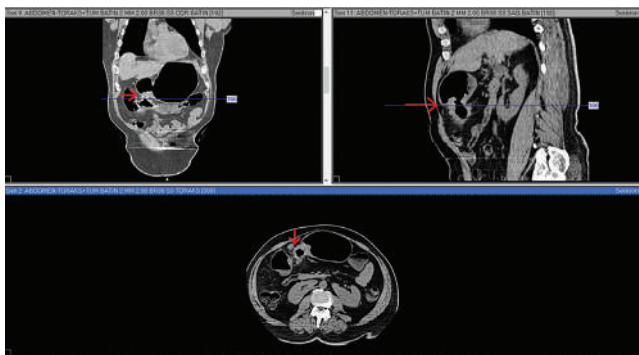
Emergency CT scan for case-1.
